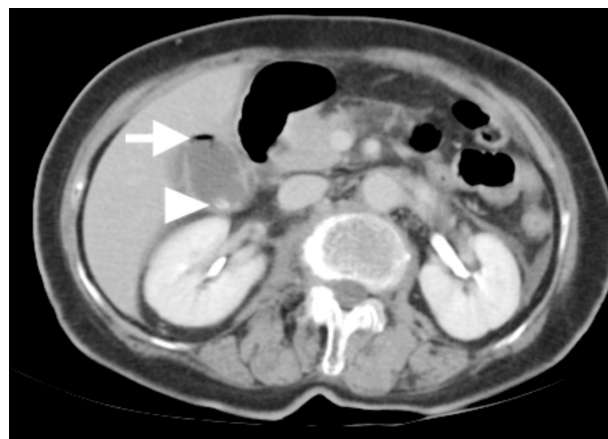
Computed tomographic scan of the abdomen after contrast enhancement showing intraluminal gas in the nondependent portion of the gallbladder (arrow) and stones in the dependent portion of the gallbladder (arrowhead)
